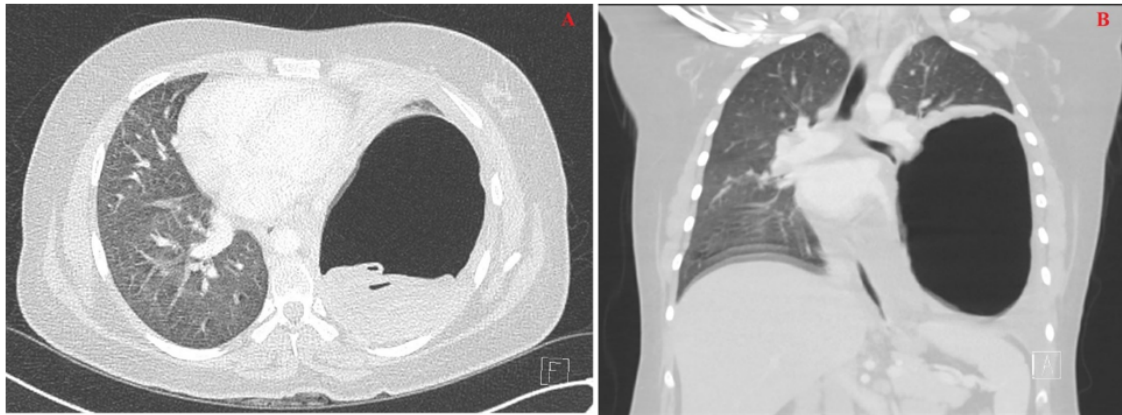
A and B: A chest CT scan showed a large left lower lobe cystic lesion measuring about 16x10 cm, with internal layering membrane seen in the dependent part in keeping with a hydatid cyst. A mild left-sided pleural effusion is seen. The mass has resulted in a mass effect with a right-sided mediastinal shift. A mass effect over the left bronchus is seen with consolidation. Multiple small right lobe areas of consolidation are seen
